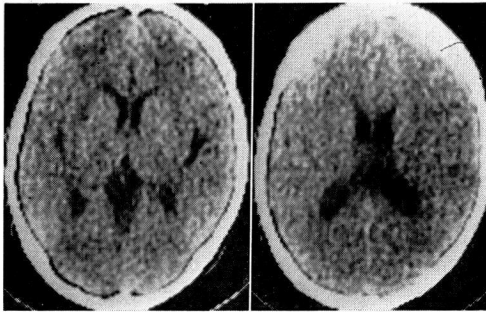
Plain CT scan of the brain demonstrating decreased attenuation of deep white matter of frontal lobes and narrowing anterior part of the lateral ventricles.
